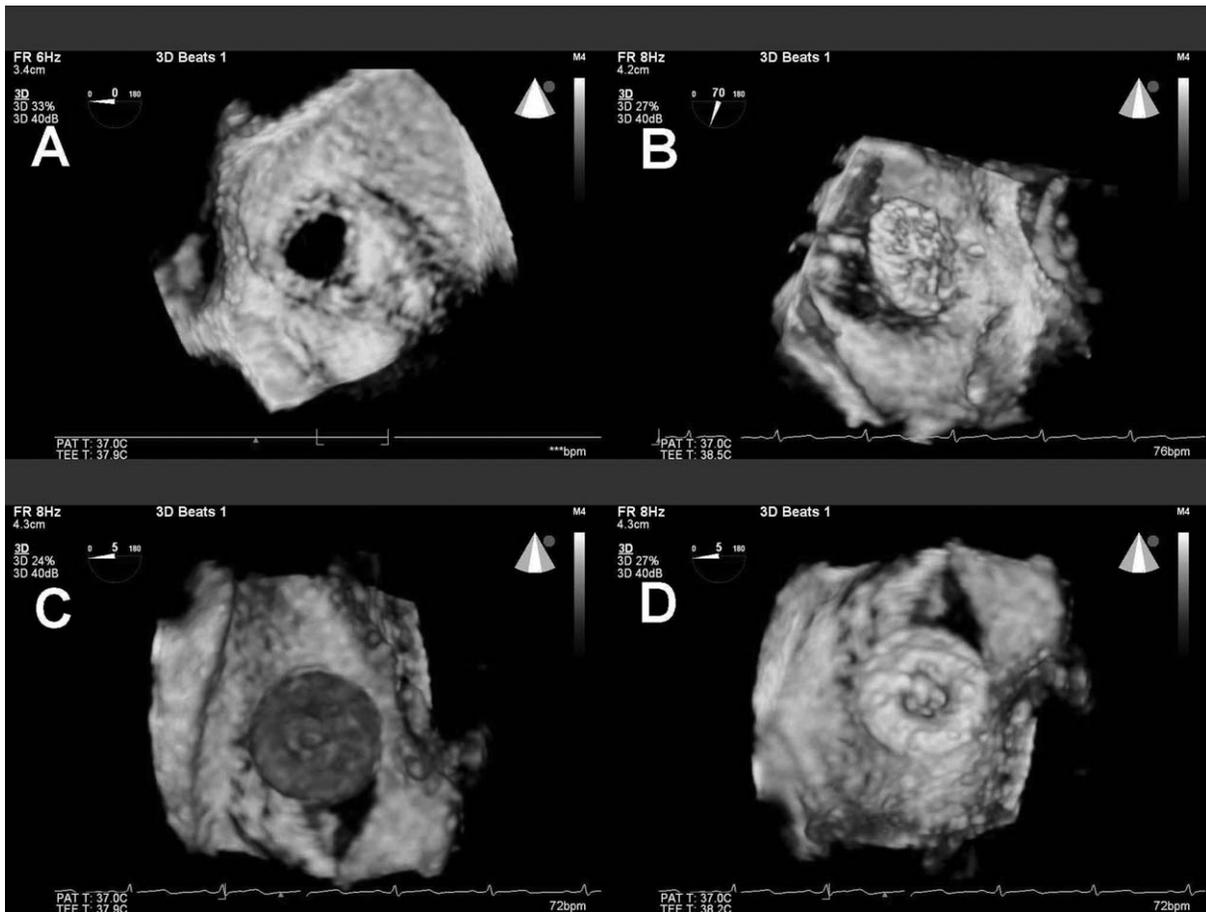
Three-dimensional TEE during the procedure. (Same patients as in 2D echocardiography). View from the left atrial side. The secundum atrial septal defect is relatively circular with good rims all around (A). Left atrial disc fully opened seen from the left atrial perspective. Note the rims of the left atrial disc formed by the reversed nitinol wire frame and the central portion of the disc composed by the thin polyester membrane. The central wire that crosses the device can also
